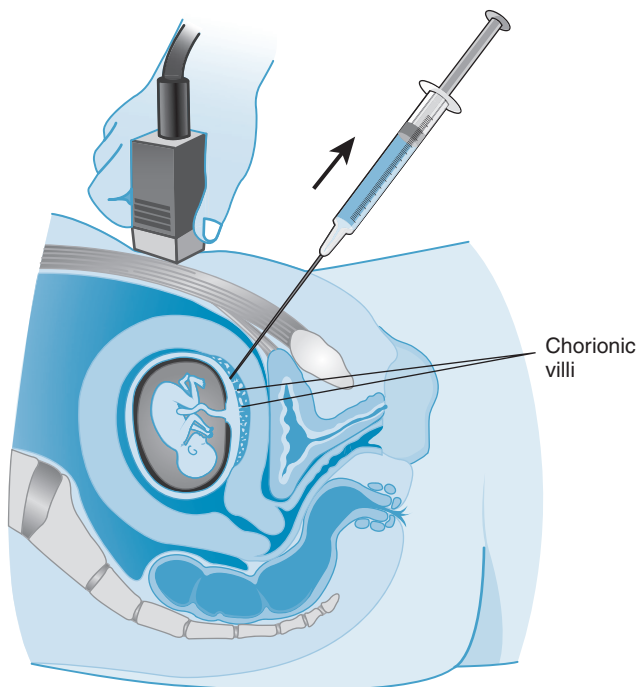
Technique for transabdominal chorionic villus sampling (CVS). A needle is guided from the patient's abdomen into the placenta under ultrasound guidance. Retrieved from http://www.uptodate.com/contents/image?imageKey=PI%2F54932&topicKey=DRUG_GEN%2F9549&source=see_link.
